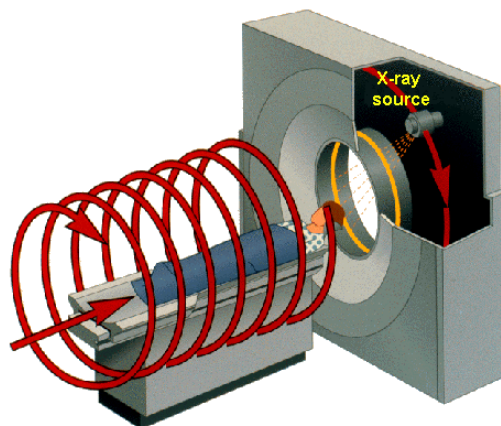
Principle of (helical) CT scanning in medicine.*
